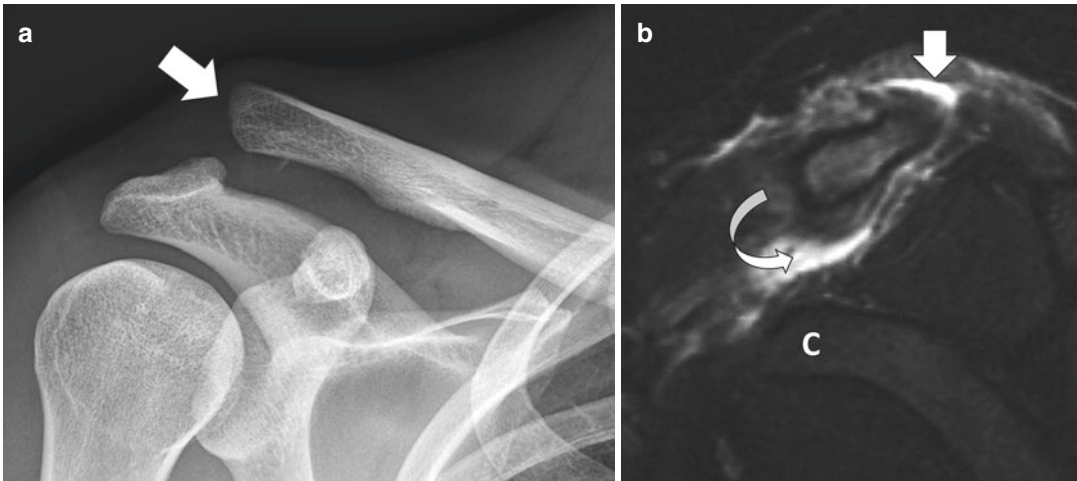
Acromioclavicular (AC) joint separation, type 3. (a) Frontal radiograph shows complete disarticulation of the clavicle (arrow) from the acromion process and an abnormally wide distance between the clavicle and the coracoid
